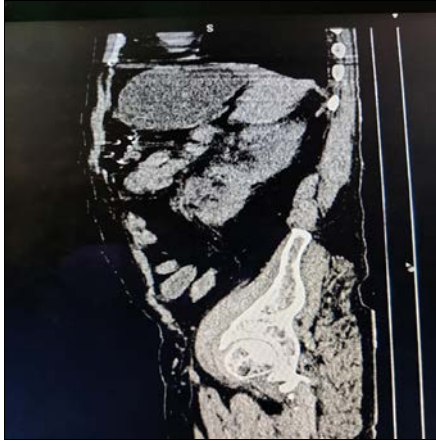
CT image (Saggital view) showing a crossed fused ectopic kidney with pyelonephritis
